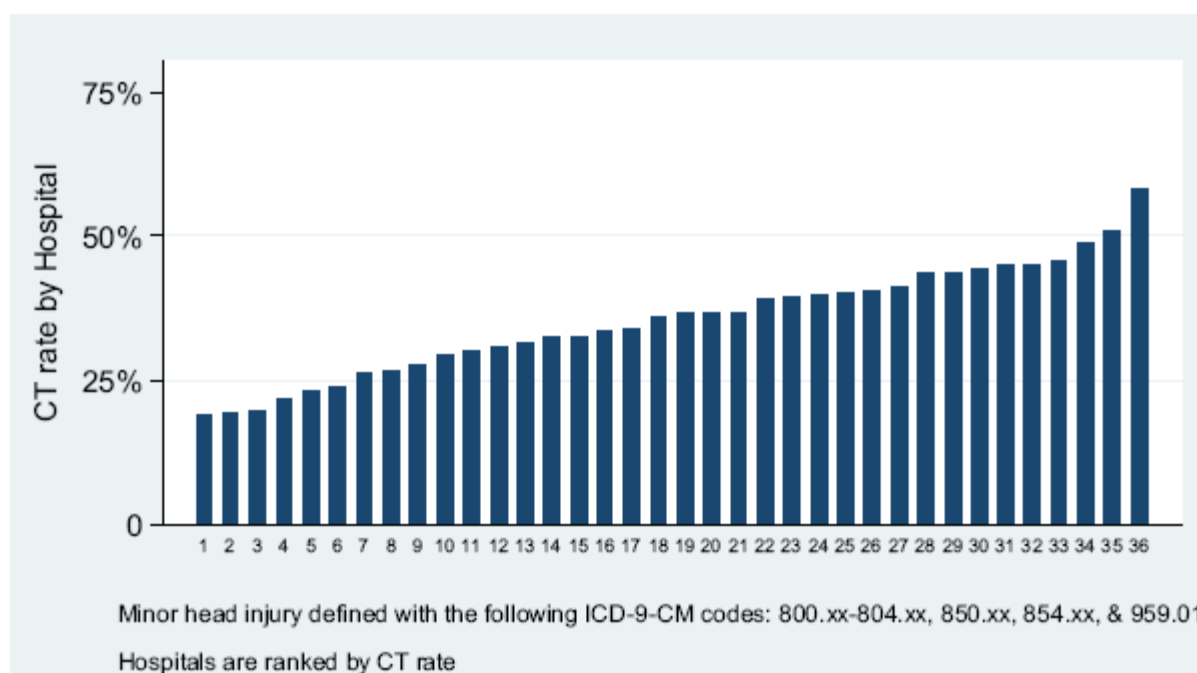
Rates of CT in pediatric patients with minor head injury discharged from the ED (n = 161 319) across a sample of pediatric hospitals in the US from 2005 to 2009.
